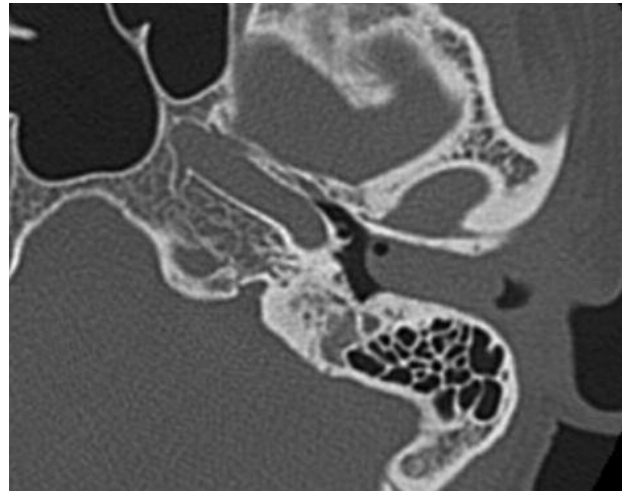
CT shows soft tissue mass locating in the deep external auditory canal and adjacent to the tympanic membrane without bony destruction
